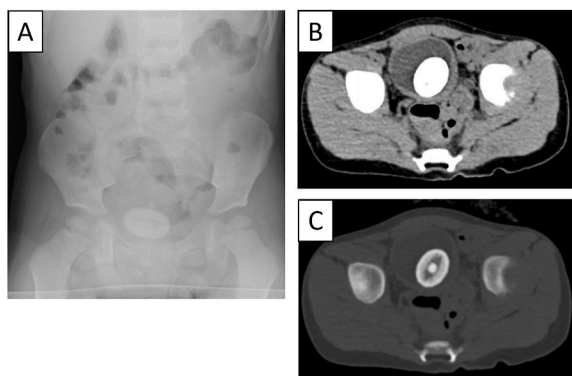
Preoperative abdominal X-ray (A) and computed tomography (B) show a bladder stone (30 mm).
